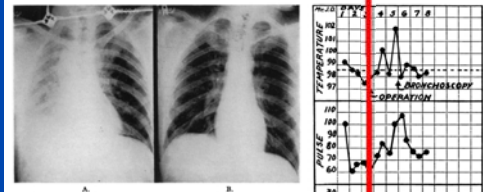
A, B. No. 32551. (A) Roentgenogram of chest following bilateral incision bronchotomy, atelectasis, right lung. Bronchotomy performed same day because of unrelieved cough and marked hypoxia. (B) Roentgenogram of chest showing bilateral lung expansion and marked improvement in respiratory status on same day. Two operations by same method on following day with equal favorable results. Chestwound satisfactory thereafter. (C) Roentgenogram six days later reveals no pulmonary atelectasis or infection.
